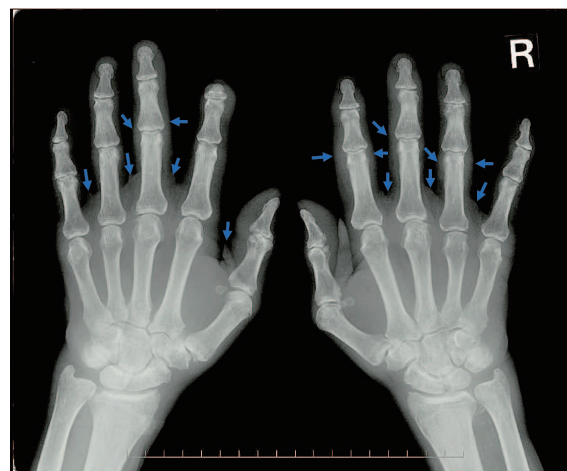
X-ray of hands showing a soft tissue swelling.
